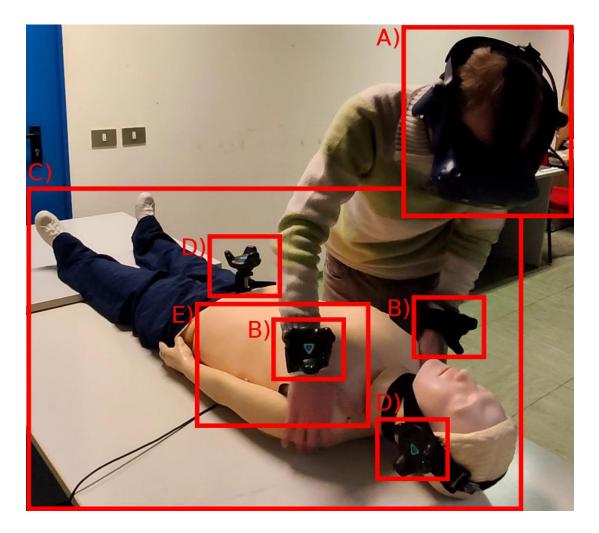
Equipment to support the proposed VR methodology for CPR training: A) VR headset with a diagonal FOV of 110 degrees and 6-DOF head tracking, B) two 6-DOF trackers that trainees wear, one for each wrist, C) physical mannequin, D) two 6-DOF trackers to synchronize mannequin position with position of the virtual person who is in cardiac arrest in VR, E) Arduino board (inside the mannequin) with ultrasonic distance sensor and temperature sensor.
